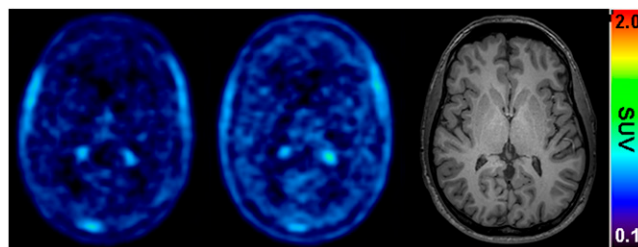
Transaxial PET summation pictures (10–40 min) of volunteer (subject 2) with greatest increase in (*R*)- ^{11}C -verapamil-derived brain activity, before (left picture) and after (middle picture) administration of tariquidar (2 mg/kg of BW). Activity concentration is expressed as SUV, and radiation scale is set from 0.1 to 2.0. Right picture shows transaxial T1-weighted MR image of same subject. Intense foci in PET images represent activity in choroid plexus and venous sinus.
